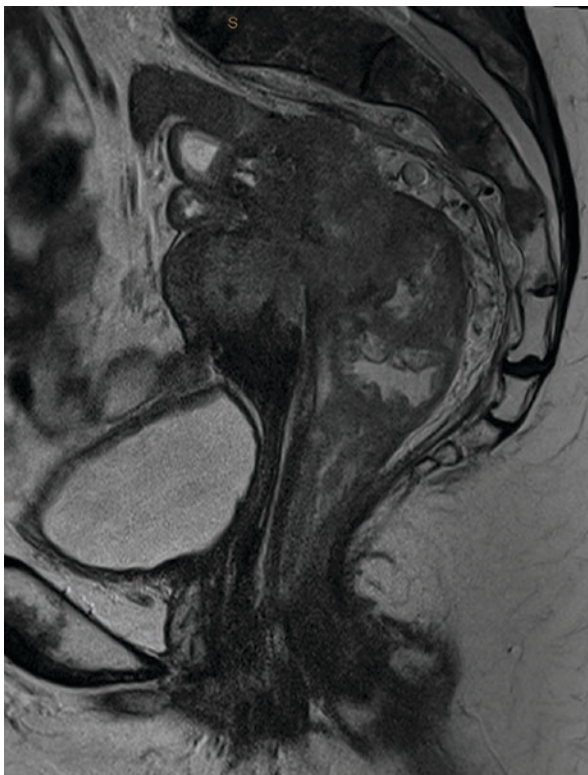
Magnetic resonance imaging (MRI) of rectal cancer
